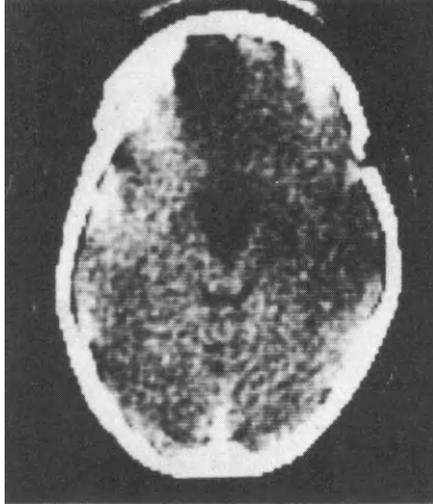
Predominantly cystic craniopharyngioma with an anterior subfrontal cystic extension. Concentration on the quality of the CT scan here will differentiate this from the frontal CT scanning artefact, which may occasionally be a problem.
